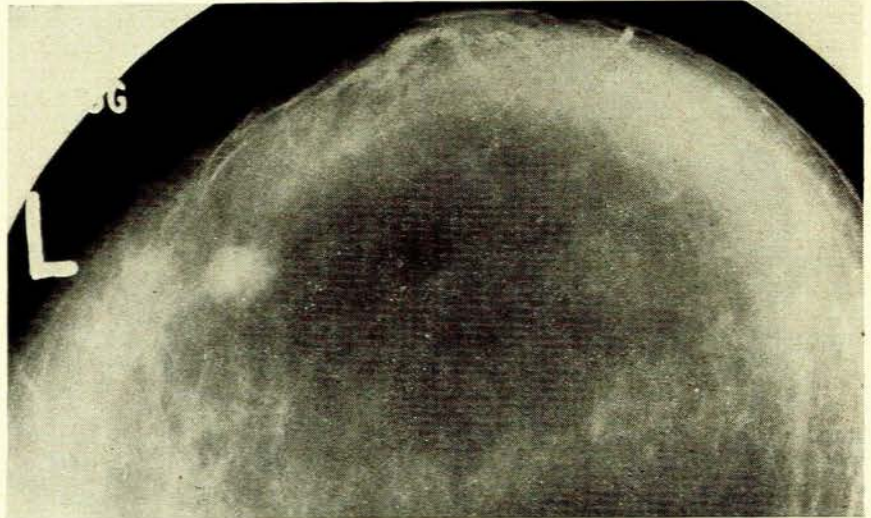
Clinically no mass palpable. Large breasts somewhat lumpy. X-ray showed small tentacled tumour, approximately 1.0 cm. in size, with infiltration and fibrillary thickening. Definite carcinoma.
